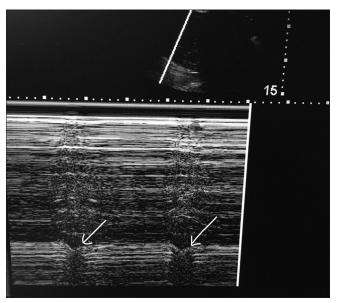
Ultrasound view of diaphragm with M-mode. The arrow points towards the inverse sinusoidal wave pattern during sniff test. This image corresponds to diaphragmatic palsy
